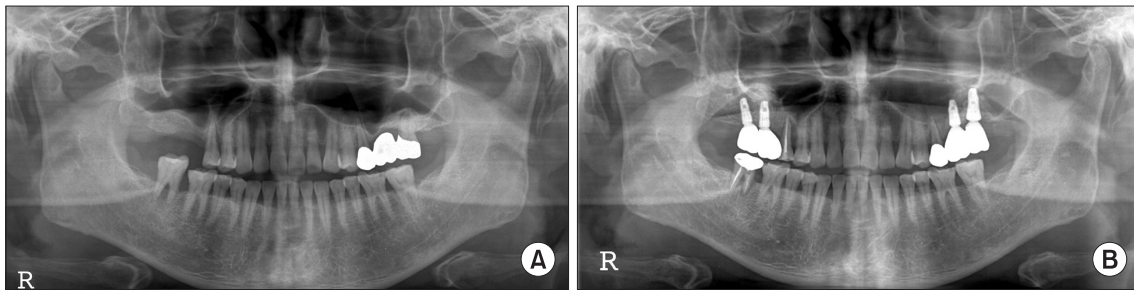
Change in alveolar bone height (Case 1). A. Preoperative panoramic radiograph. B. Panoramic radiograph 78 months after sinus-bone graft.
